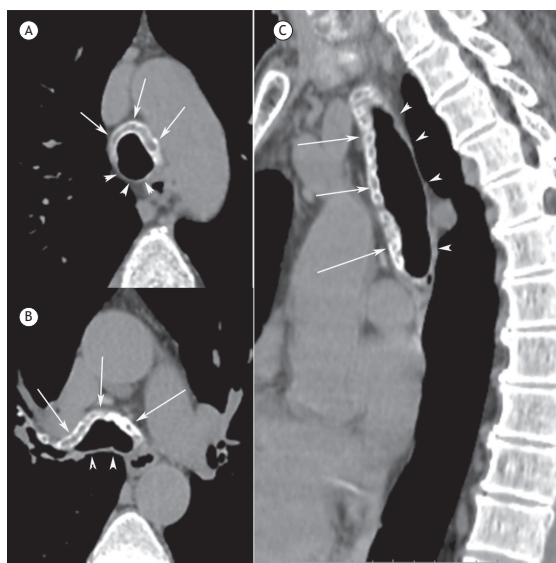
Axial CT slices (in A and B) and coronal CT reconstruction (in C) showing diffuse thickening of the anterior wall of the trachea and main bronchi, with calcifications (arrows). Note that the posterior wall (arrowheads) is spared.
